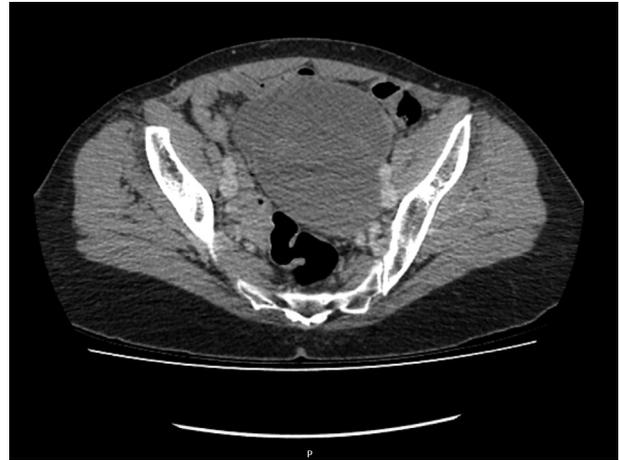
CT of the pelvis.
